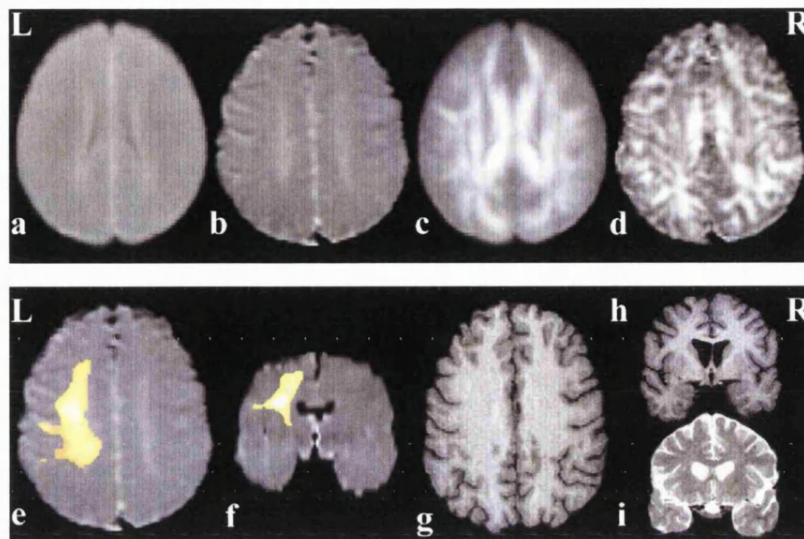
Patient 1. Normalised axial mean diffusivity maps at the same slice position for the averaged 30 control subjects (a) and the patient (b) and (e). Normalised coronal mean diffusivity map (f). Normalised axial anisotropy maps at the same slice position for the averaged 30 control subjects (c) and the patient (d). The difference in signal to noise between the maps is due to averaging of the 30 controls subjects. The region of significantly increased mean diffusivity is superimposed on maps (e) and (f). The equivalent slices of the patient's T1-weighted axial (g) and coronal (h) and T2-weighted coronal (i) images show no abnormality. The region in (e) was used for quantitative region-of-interest analyses of mean diffusivity values. Note that right on the images is patient's right.
